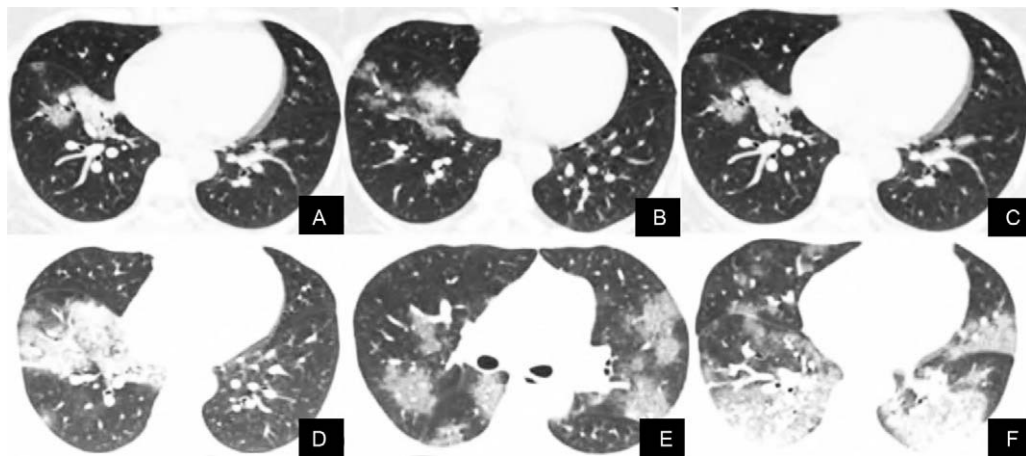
The CT images of a 33-year-old woman with new coronavirus pneumonia shows the progression of the disease. A–B. The first CT scan showed flaky ground glass shadows in the lower lobes of both lungs. C–D. Three days later, the lesions were enlarged, accompanied by consolidation and thickening of interlobular septa. E–F. CT images re-examination 8 days later showed the fusion of large ground glass shadow, consolidation shadow, and interlobar pleural thickening. CT=computed tomography.
